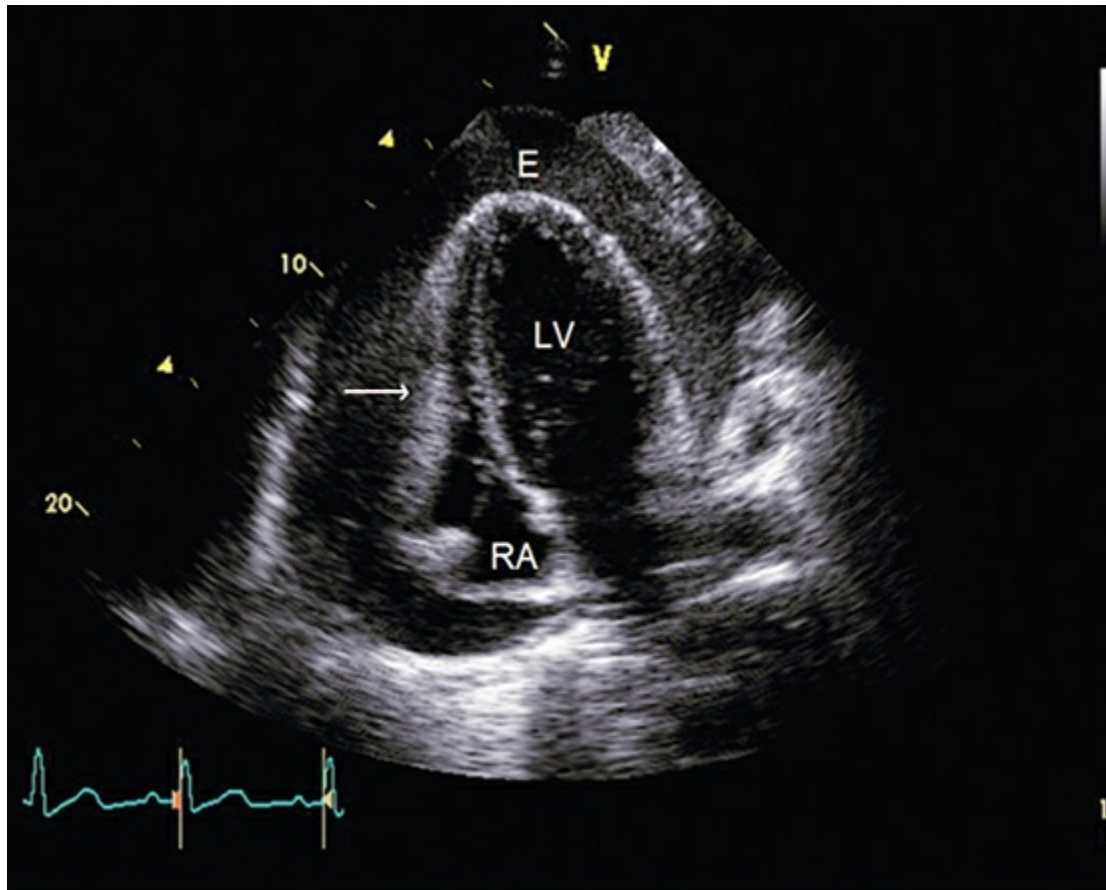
Right ventricular compression (arrow) in cardiac tamponade (apical four-chamber plane).
